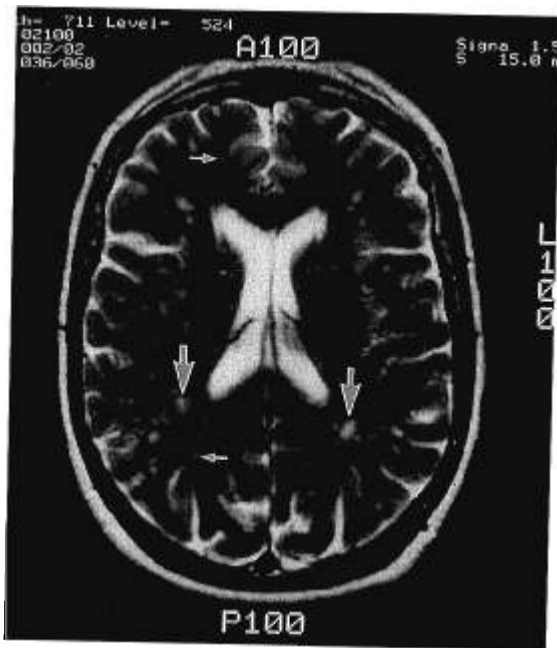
T₂-Weighted axial magnetic resonance imaging scan of brain in patient with nonarteritic anterior ischemic optic neuropathy (patient 9), shows typical white matter lesions (large arrows). Smaller, smoothly rounded densities (small arrows) probably represent perivascular spaces and were not tabulated.
